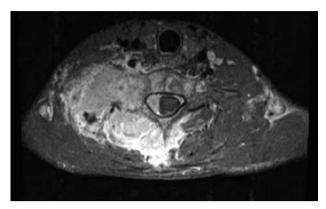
T1-weighted MRI image showing a large right posterior paraspinal mass at C6-7 level (hyperintense whitish soft tissue) with intraspinal epidural extension and early compression of the spinal cord.
